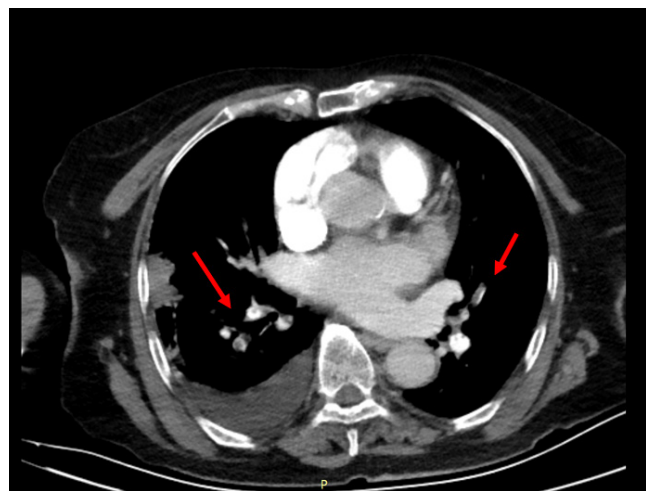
At computer CT filling defects consistent with thromboembolism were observed, showing lobar and segmental branches extending from the distal of both pulmonary arteries
